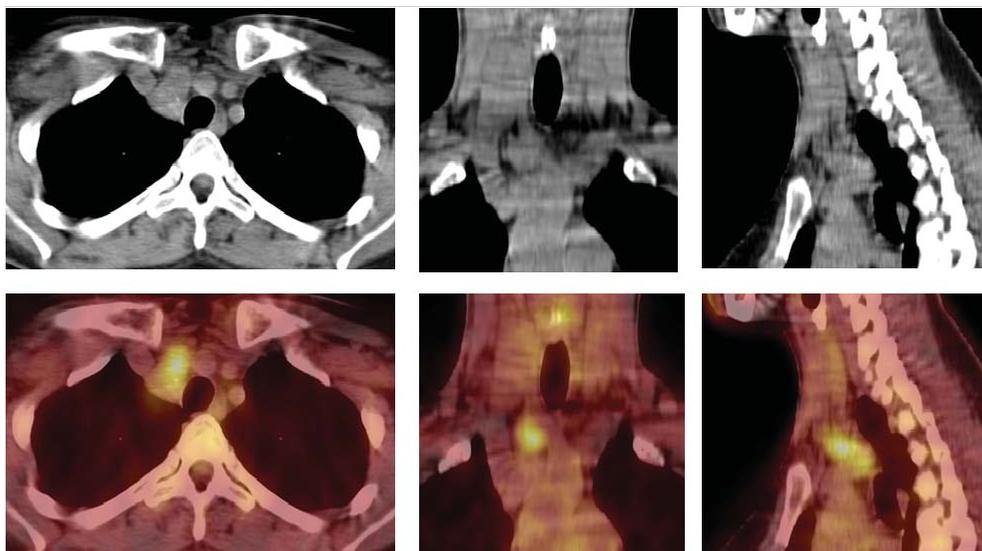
Axial (left column), coronal (middle column), sagittal (right column) images of FDG PET-CT show the lesion, 3.2 x 2 x 4.5 cm in size which is located in right paratracheal region on the level of jugulum and extended inferiorly to arcus aorta with high FDG uptake (SUVmax: 5.2).
